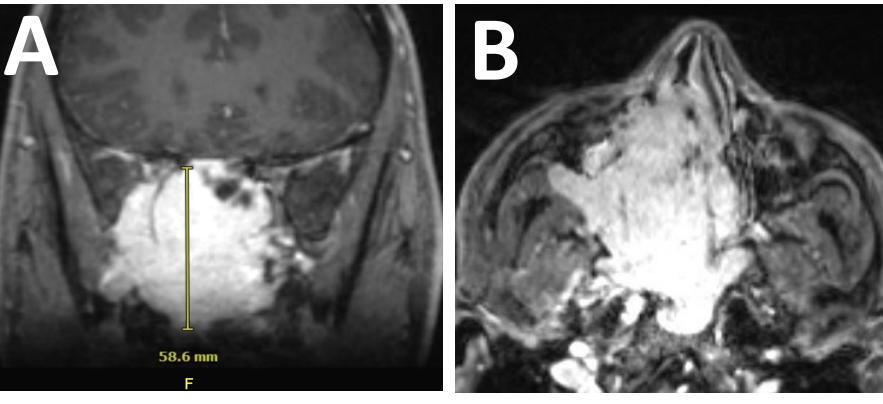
(A) Coronal and (B) axial cuts of a T1 post-contrast MRI brain demonstrating a contrast-enhancing mass measuring 8.9 x 5.0 x 5.9 cm with infratemporal fossa and middle cranial fossa involvement and extension into the anterior aspect of the right cavernous sinus with partial encasement of the right cavernous internal carotid artery.
